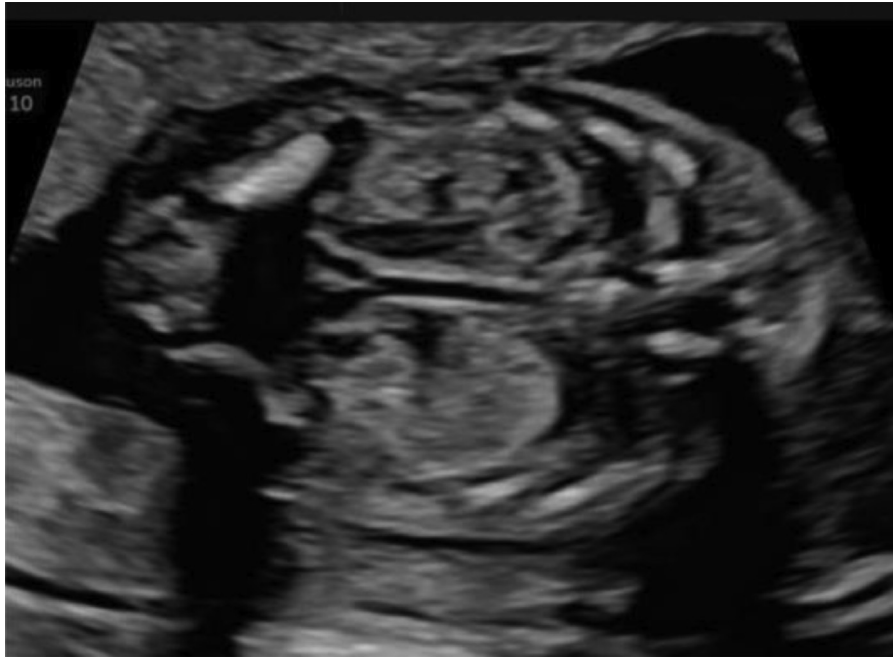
Prenatal grayscale ultrasound at 19 wk gestational age (GA) in the coronal plane reveals hyperechoic, enlarged kidneys bilaterally, measuring 2.1 AP x 1.2 transverse cm on the left and 2.2 AP x 1.1 transverse cm on the right. The normal range for GA should not exceed 1.5 cm in AP diameter.
